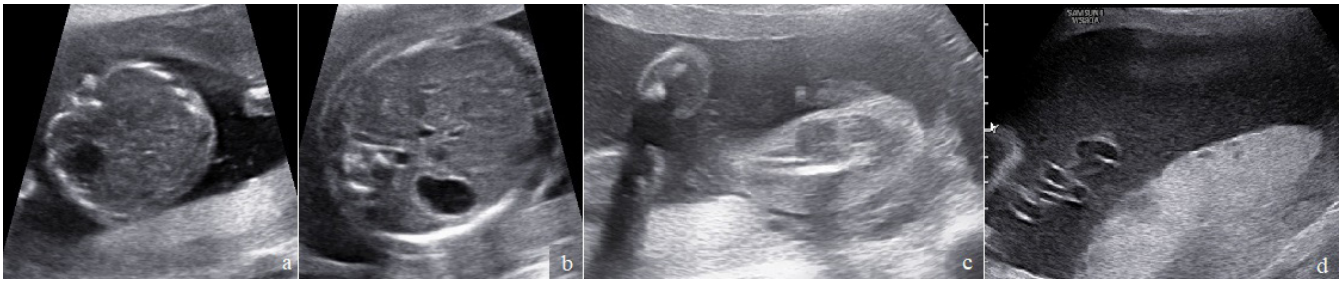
Section of the fetal abdomen and ultrasound image of the amniotic fluid: a) a section of the fetal abdomen at the level of the stomach at 18 weeks of pregnancy, b) the same section at 25 weeks of pregnancy, a double contour is noted, c) the sex of the fetus is male, d) multiple inclusions in the amniotic fluid.
